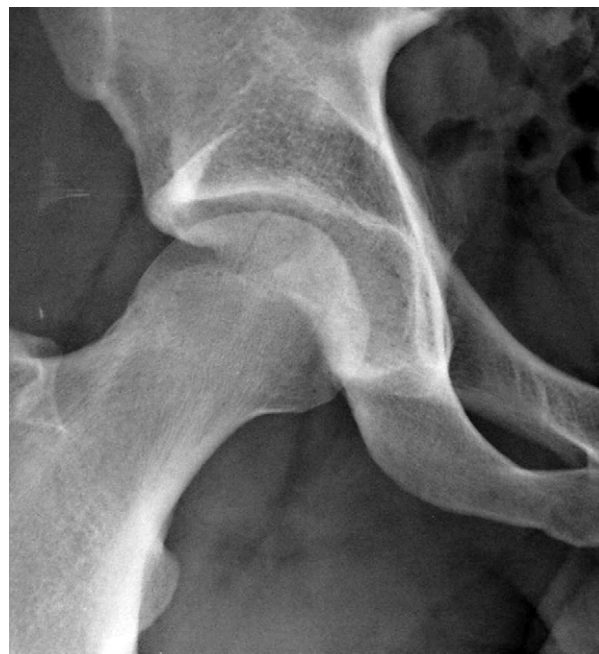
Anteroposterior pelvic radiograph following reduction.
